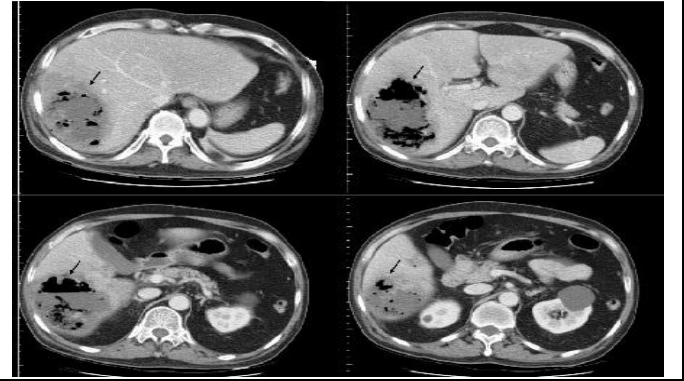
Abdominal computed tomography revealing a huge gas-forming liver abscess (arrows).
